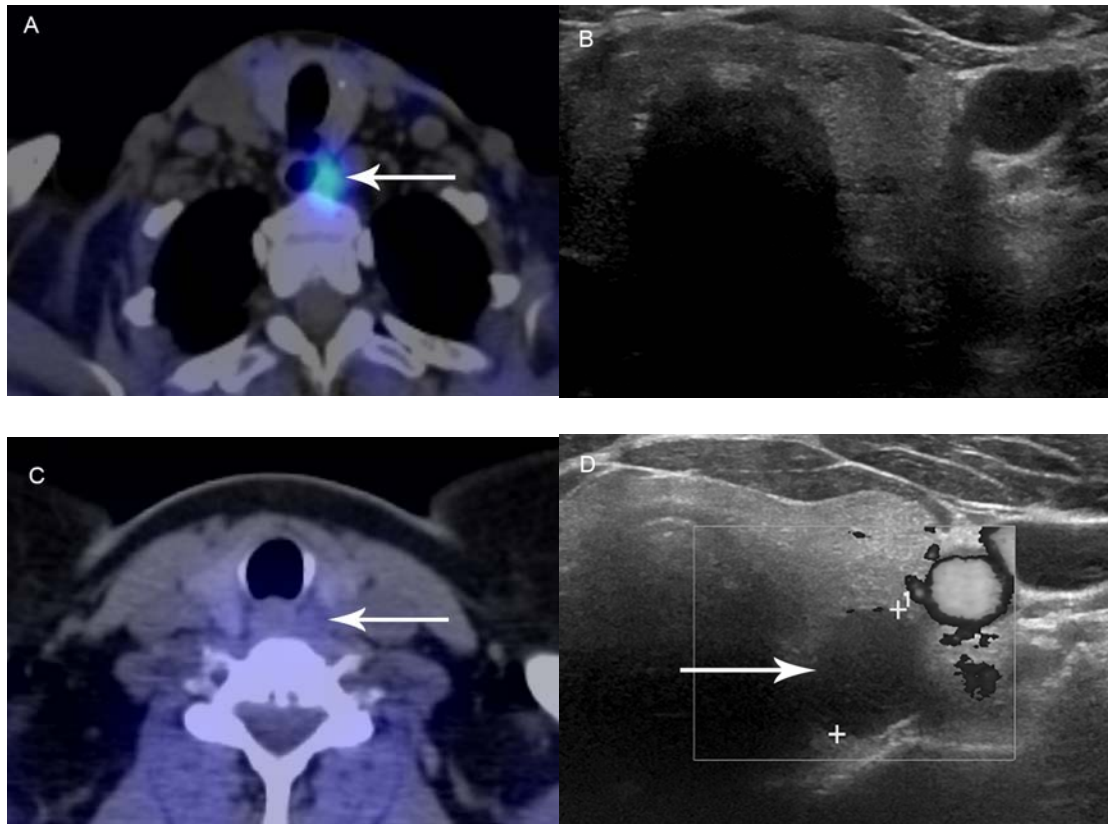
Examples of discrepancies between modalities. Series of images demonstrating discrepancies between the modalities. A) Avid tracer uptake is seen on fused SPECT-CT images within a left superior parathyroid adenoma (arrow), which is located deep in the tracheo-oesophageal groove. This is not visible on the corresponding ultrasound (B) due to acoustic shadowing from the trachea, but was subsequently located at surgery. C) Fused SPECT-CT image reveals no tracer retention in a nodule posterior to the left lobe of the thyroid (arrow). D) There are characteristic appearances of this nodule (arrow) on ultrasound for a parathyroid adenoma, which has exhibited early washout with sestamibi. This was subsequently confirmed at surgery.
